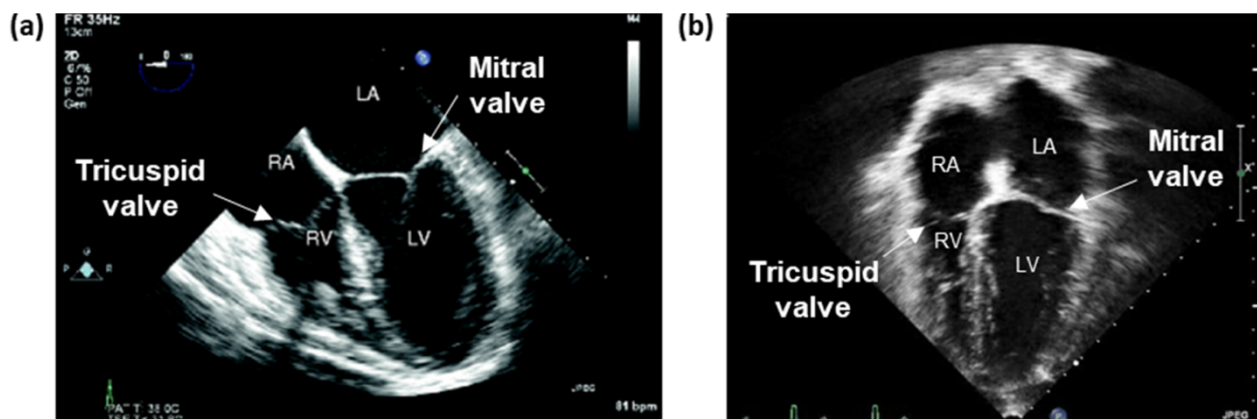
Echocardiographic imaging modalities: (a) a four-chamber mid-esophageal view using transesophageal echocardiography (TEE) with image modified from [58] and (b) an apical four-chamber view (A4C) using transthoracic echocardiography (TTE).
